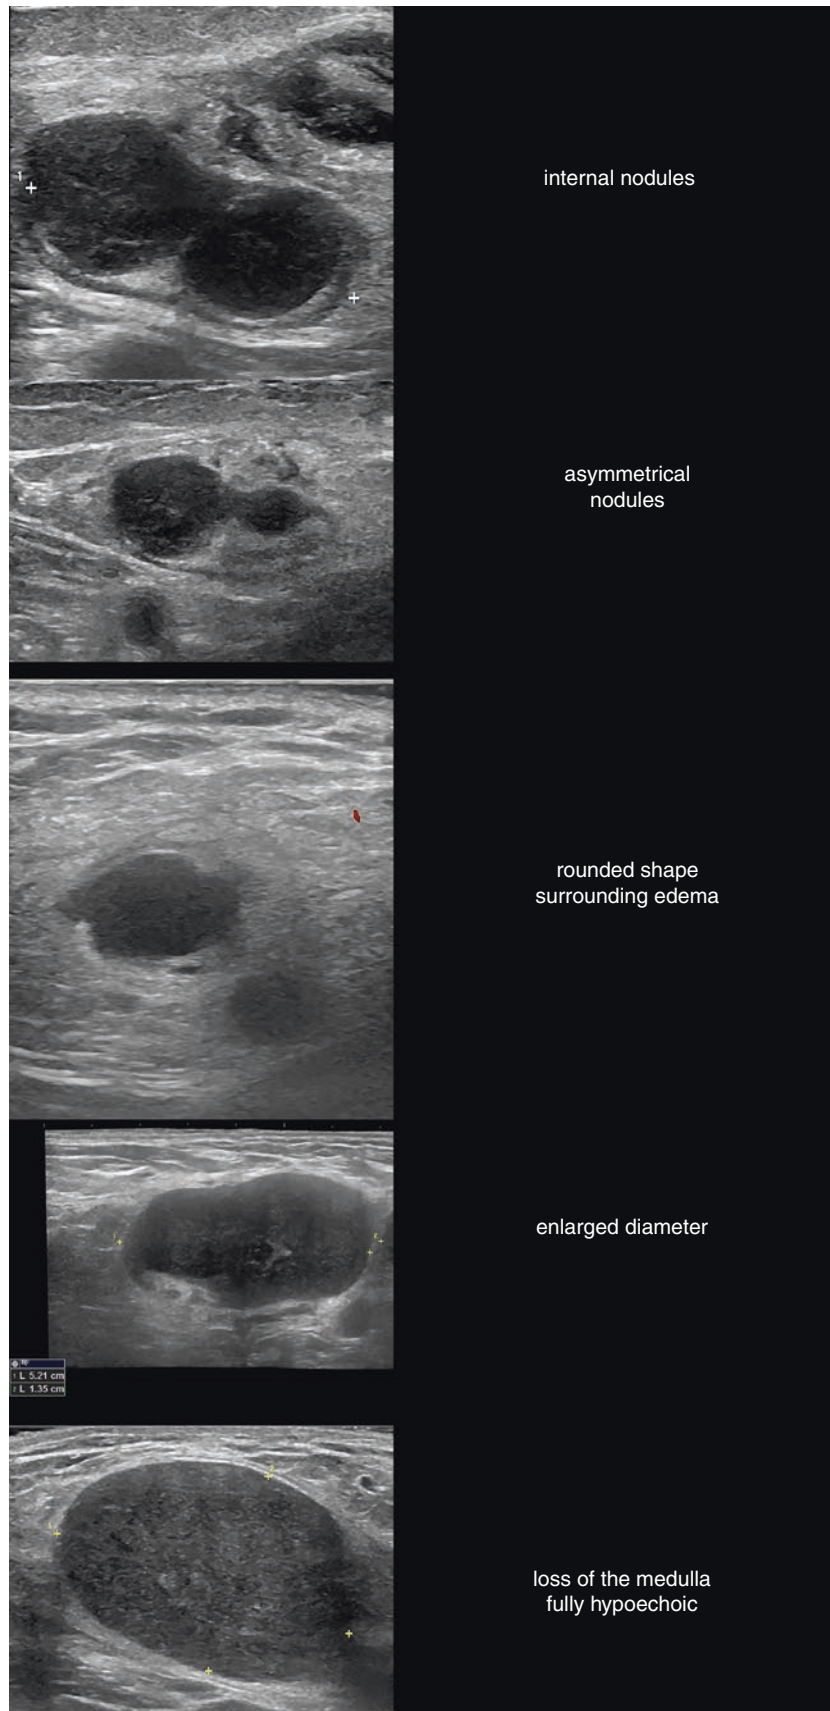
Ultrasound morphologies in greyscale, suggestive of malignant lymph nodes.
